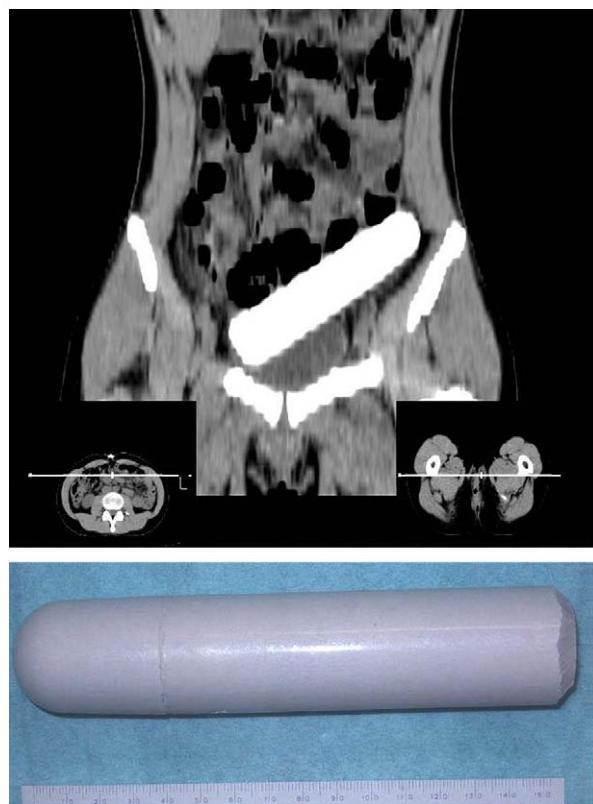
Upper*, computed tomography scan showed the prosthesis migrated into the peritoneum. *Lower*, the removed vaginal prosthesis, made of silicone, was 14 cm long and 3 cm across.
